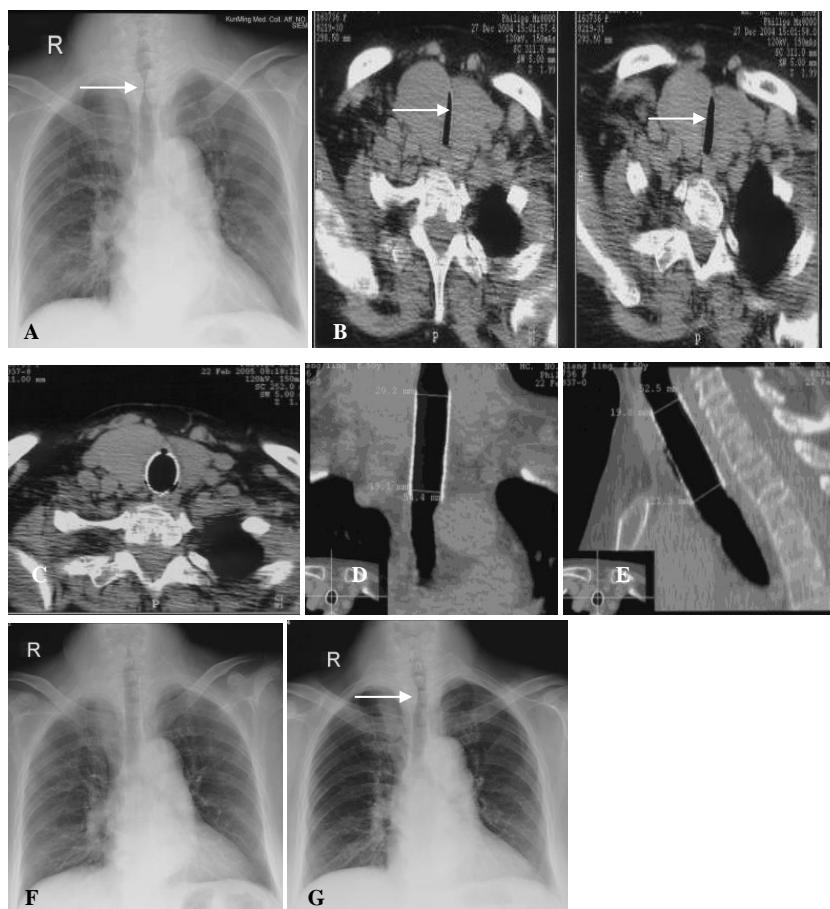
Chest film (A) and CT neck scan (B) before a stent was put within the trachea. The thyroid gland was greatly enlarged and compressed the trachea with significant stenosis. After a stent was deployed within the stenotic trachea (C-F), CT scan demonstrated the stenosis had disappeared and the tracheal diameter had returned to normal. The stent had been withdrawn after thyroid arterial embolization (G), and the right thyroid lob was still enlarged to compress the trachea (arrow).
